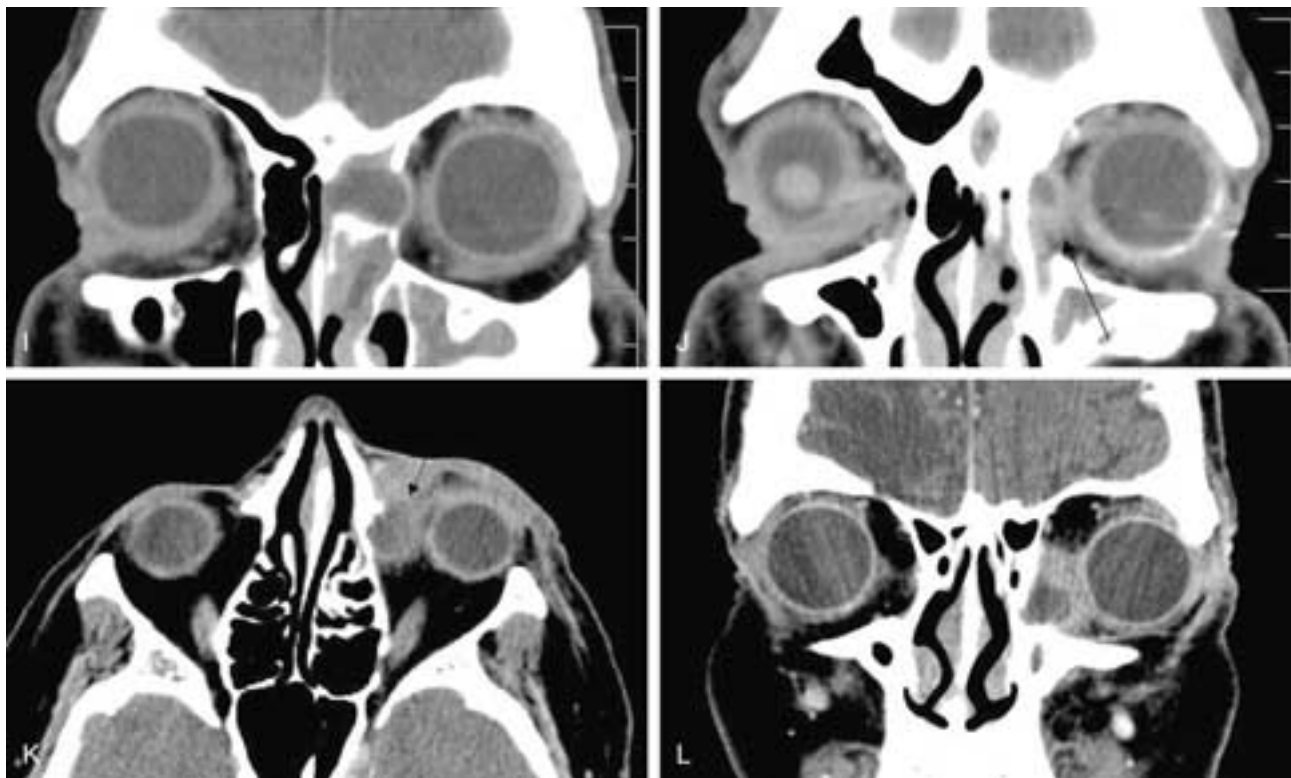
Continued.* I and J, Coronal CT scans shows lateral displacement of the lamina papyracea and lacrimal fossa bed, as well as inflammatory changes of the lacrimal sac and surrounding tissues (*arrow*), with loss of normal tissue planes. Pathology: dacryocystitis secondary to anterior ethmoid inflammatory disease—mucocoele. K and L, Fifth patient. Axial and coronal CT scans show a distended lacrimal sac with thickened walls, extensive preseptal swelling, and loss of adjacent tissue planes (*arrow*). Incidental right frontal lobe encephalomalacia. Pathology: lacrimal sac abscess.
